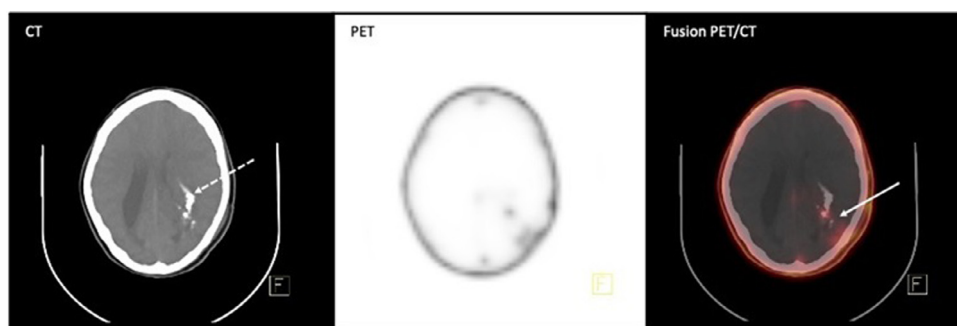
PET, CT, and Fusion PET/CT images of a Thirty-three-year-old lady with a history of worsening headache from few months ago and new-onset seizure diagnosed with a left occipito-parietal mass spreading to lateral ventricle and basal ganglia (not shown). Excisional biopsy revealed Oligodendroglioma (WHO III). She was referred for in vivo evaluation of CXCR4 expression. Dashed arrow is pointing the calcification. Solid arrow shows minimal residual tumoral tissue.
